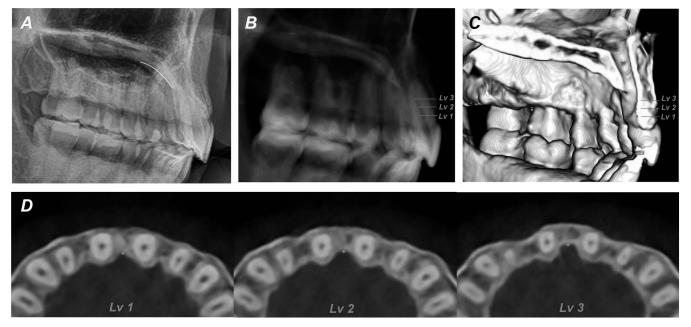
Palatal alveolar bone images of a sample (at retention). (A) Cephalometric image. (B) Cone-beam computed tomography (CBCT) image (grayscale mode). Landmarks of the interdental palatal bone depression. (C) CBCT image (bone mode). Landmarks of the interdental palatal bone depression. (D) Axial sections of CBCT image. Landmarks of the interdental palatal bone depression. Lv indicates level.
